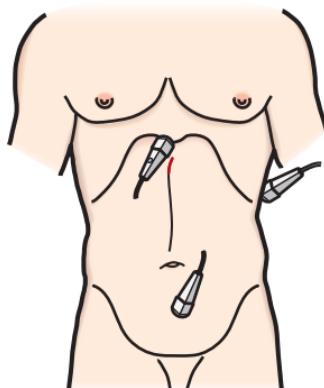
Placement of ultrasound probe for FAST.
